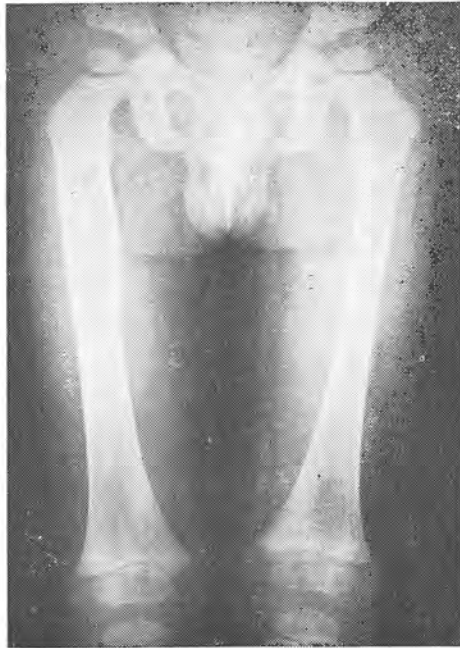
X-ray photos of the femur obviously showed marked difference in size of the osteolytic lesions before and after treatment (left and right respectively).
